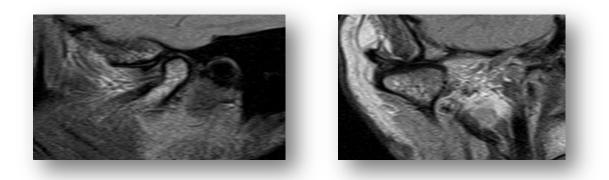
MRI, Oblique-Sagittal Section PD Fig. 5b - MRI, Oblique-Coronal Section PD
